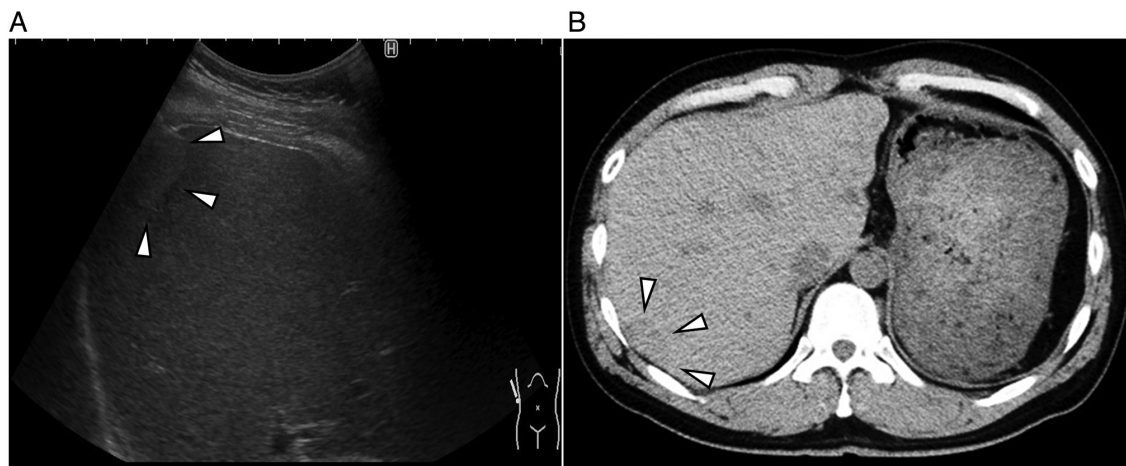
Abdominal ultrasonography and abdominal plain-computed tomography imaging of the IHS. (A) An abdominal ultrasonography revealed a 2.4x1.4 cm isoechoic lesion (arrows) with a hypoechoic zone at the margins in segment 7 of the liver. (B) An abdominal plane-computed tomography scan revealed a hypodense mass (arrows) measuring 2.5x1.7 cm in segment 7 of the liver.
